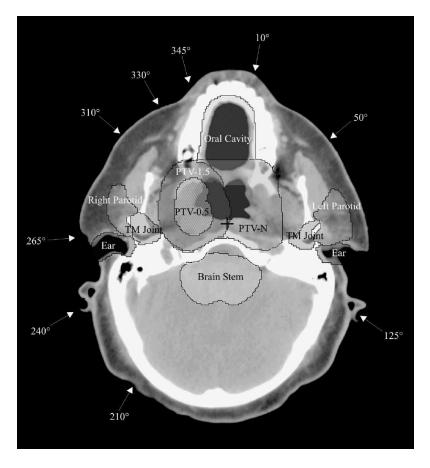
A CT slice of Patient 2 seen from below, with delineated PTV's and OR's. The cross represents the isocenter and the arrows represent the angles for the optimized beam configuration from the first run.
